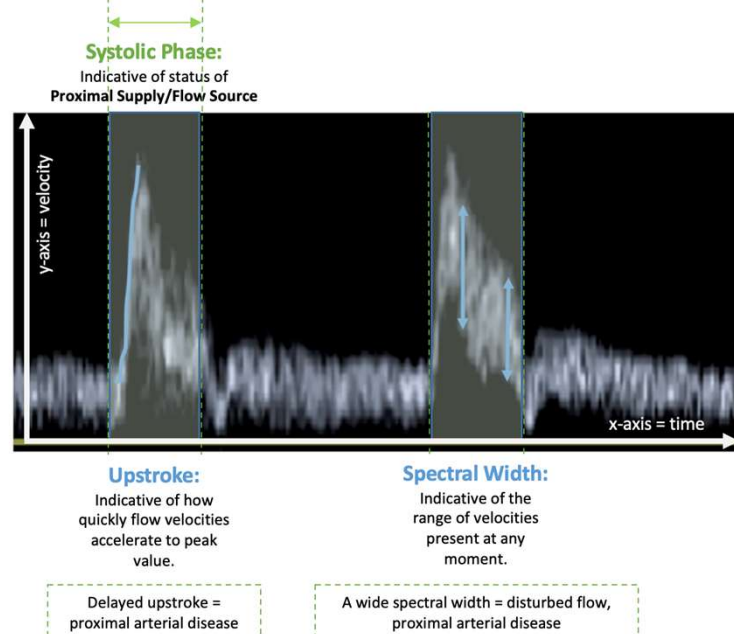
Systolic phase of a spectral Doppler arterial waveform.<sup>6</sup>
